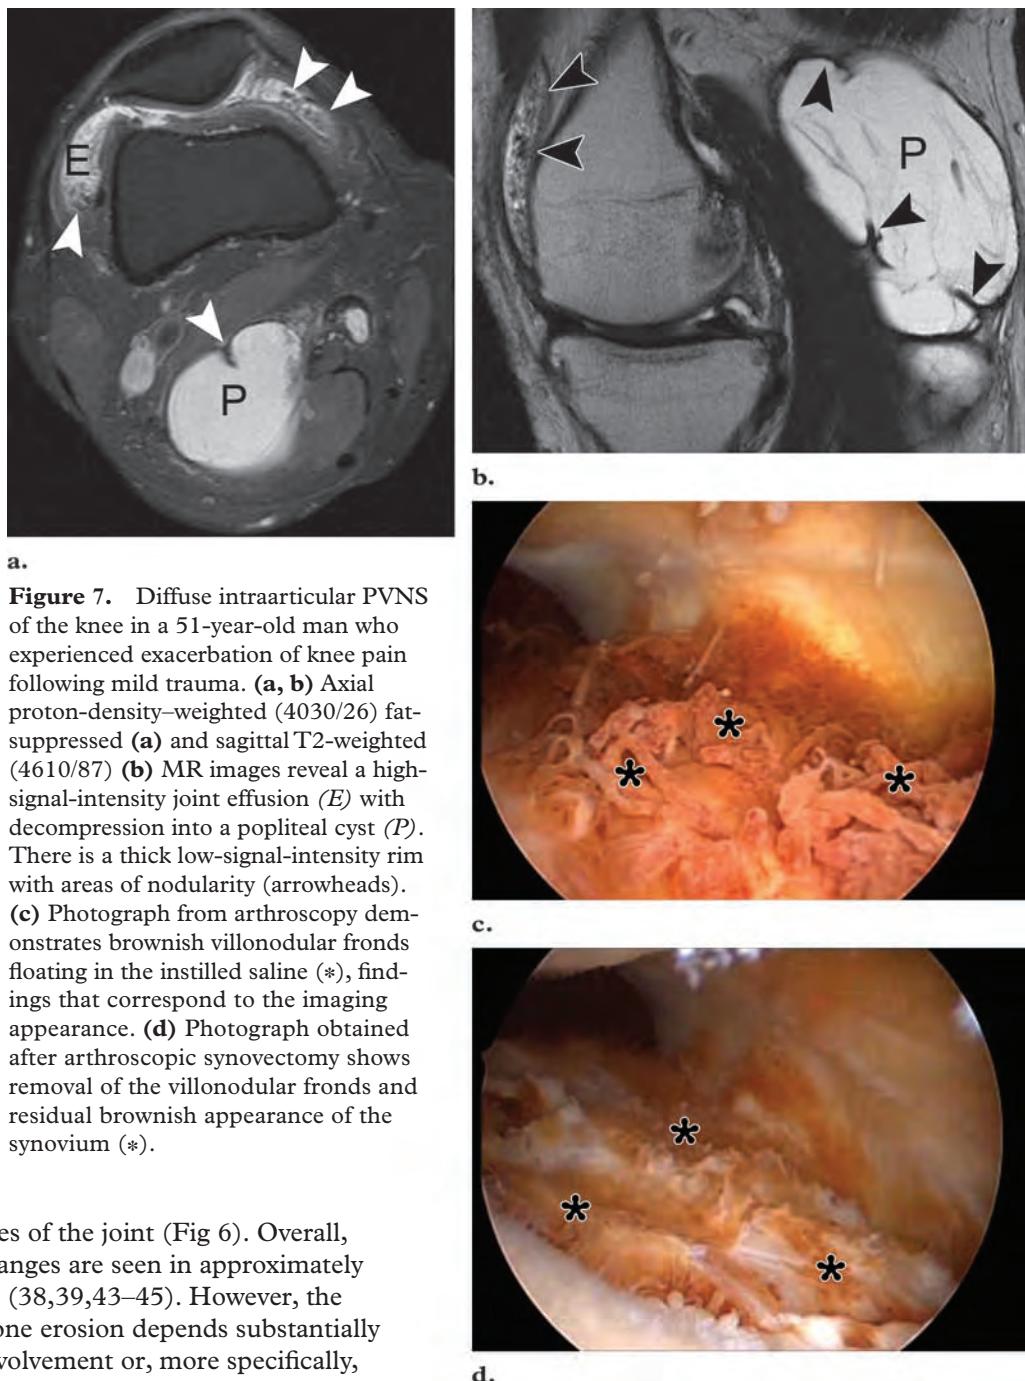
Diffuse intraarticular PVNS of the knee in a 51-year-old man who experienced exacerbation of knee pain following mild trauma. (a, b) Axial proton-density-weighted (4030/26) fat-suppressed (a) and sagittal T2-weighted (4610/87) (b) MR images reveal a high-signal-intensity joint effusion (*E*) with decompression into a popliteal cyst (*P*). There is a thick low-signal-intensity rim with areas of nodularity (arrowheads). (c) Photograph from arthroscopy demonstrates brownish villonodular fronds floating in the instilled saline (*), findings that correspond to the imaging appearance. (d) Photograph obtained after arthroscopic synovectomy shows removal of the villonodular fronds and residual brownish appearance of the synovium (*).
